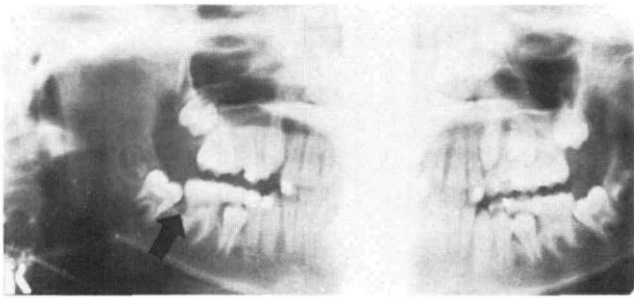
Radiograph of lesion, case 1.
